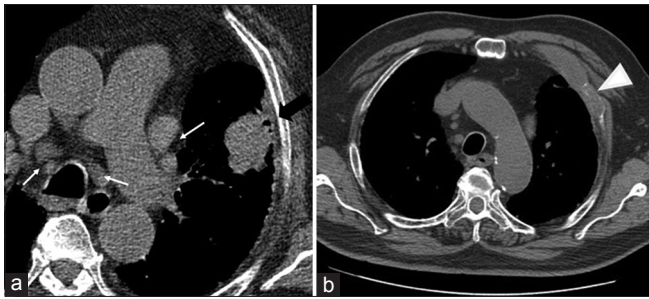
(a) Transaxial computed tomography attenuation correction slices showing the primary lung tumour (black arrow) and multiple pathological mediastinal lymph nodes (white arrows). (b) Staging CT showing anterior chest wall metastases and rib destruction (arrow head)
